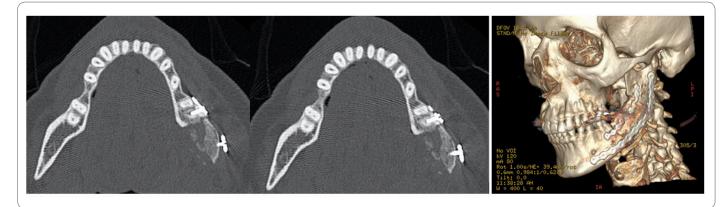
CT scan after surgery showed roots lesion by the screws.
